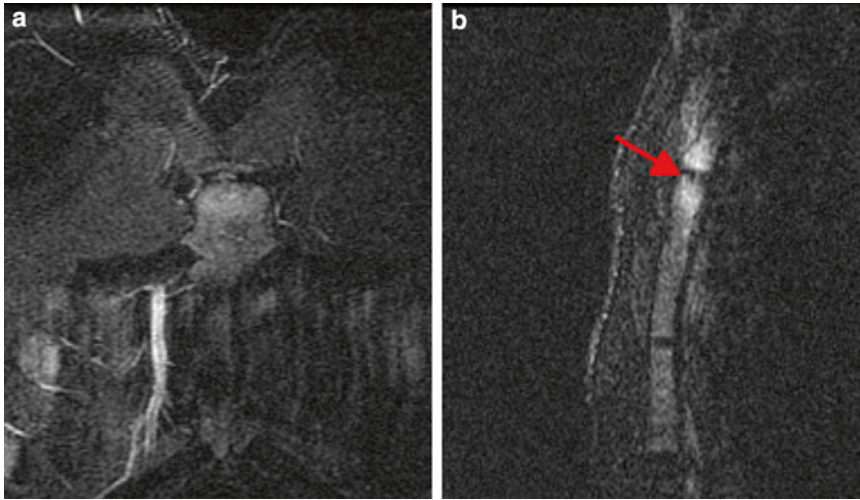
T2 coronal (a) and sagittal (b) MRI series demonstrating stress fracture of the mid sternum in a competitive weight lifter
